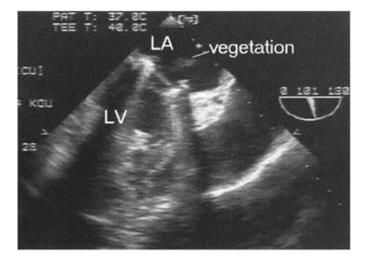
Vegetation attached to the mitral prosthetic valve ring demonstrated by transesophageal echocardiography. LA: left atrium; LV: left ventricle.
